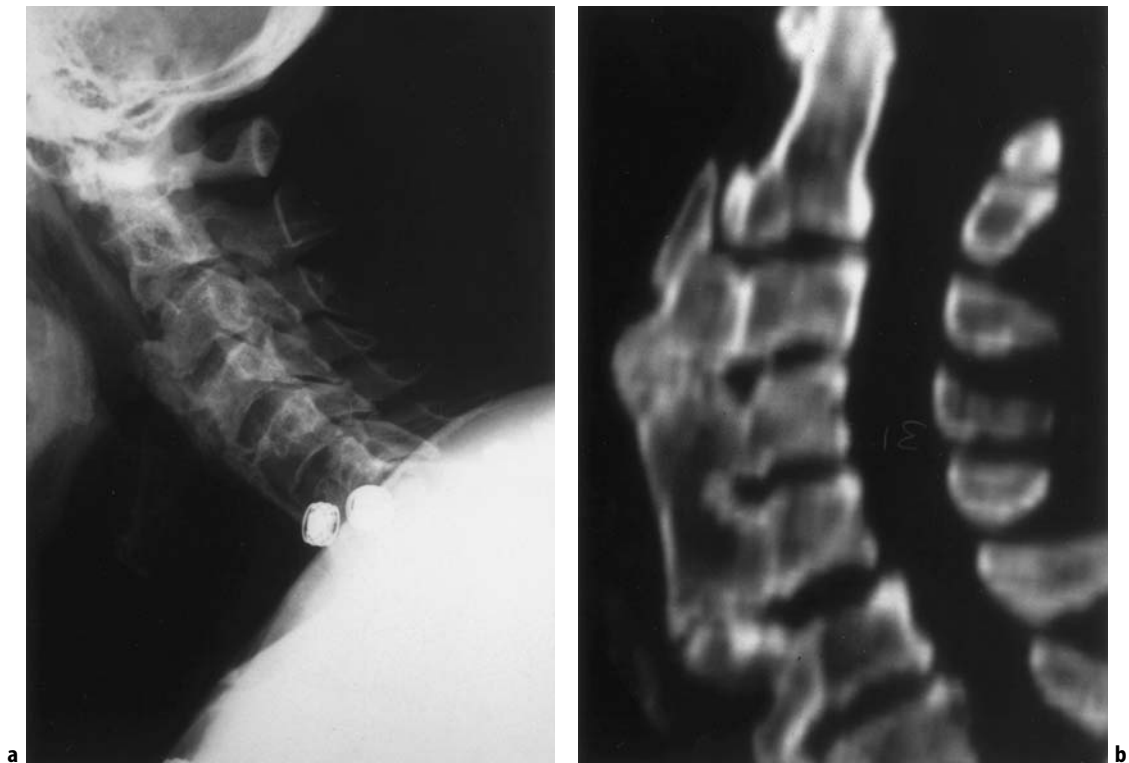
DISH. Lateral X-ray a and CT scan reconstruction b of the cervical spine, demonstrating thick ossification anterior to the vertebral bodies from C2 to C6. The process involves the anterior aspect of the vertebral bodies only, without encroaching upon the spinal canal. This patient presented with dysphagia.
